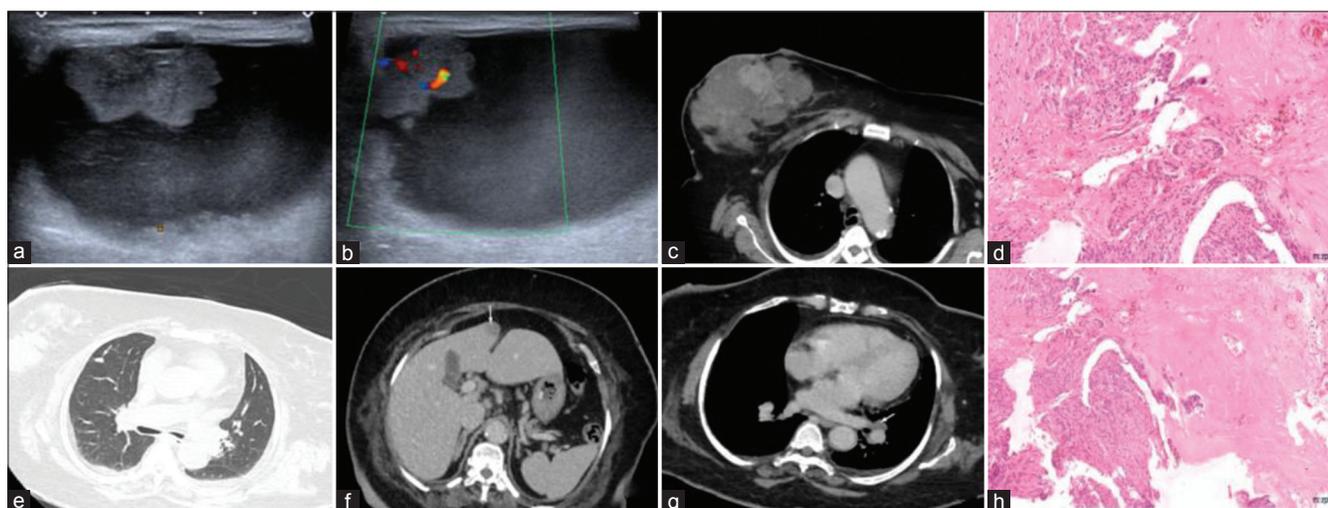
(a,b) Grey scale ultrasound reveals an irregular poorly circumscribed solid cystic lesion in right breast. Breast imaging reporting and data system category- 4C; (c) CT-scan reveals irregular solid cystic lesion with overlying skin thickening in the right breast. Solid component shows intense enhancement. Contrast-enhanced computed tomography scan reveals (e) suspicious right lung nodule; (f) hypodense lesion in liver; and (g) left hilar lymph node-suspicious for metastasis; and (d,h) HPE malignant adenomyoepithelioma
